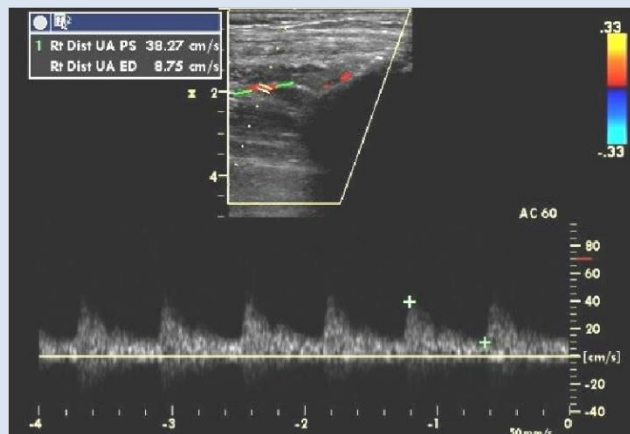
Biphasic waveform pulse wave doppler of right ulnar artery. (Peak Systolic Velocity 38.27 cm/s)
